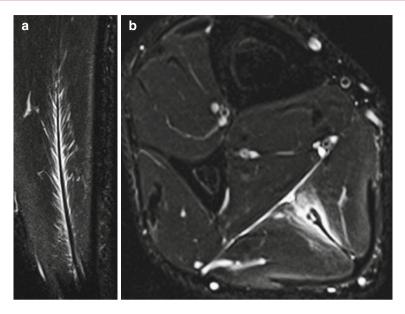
Sagittal (a) and axial (b) MR images of soleus muscle injury. Edema can be seen at the musculotendinous junction in a characteristic feather-shaped pattern (grade 1 injury) (Reprinted with permission of Thieme [25])
